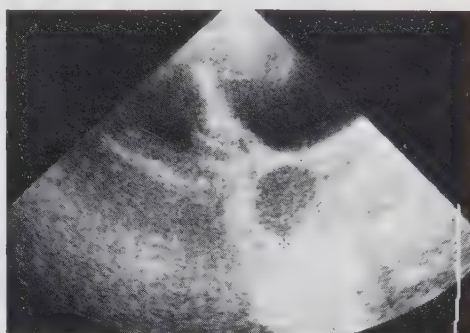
A typical ultrasound representation of a luteinized unruptured follicle. The woman had used NORPLANT-2 since more than three years. The picture is taken on cycle day 23.
